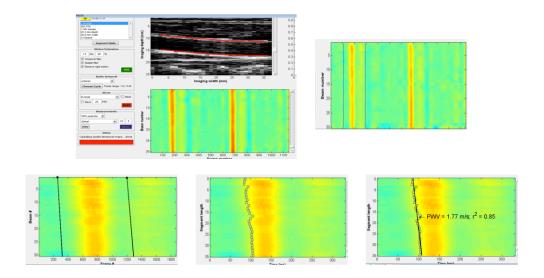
High image quality. The vessel walls are easy to demarcate (ultrasound image) and motion corresponding to two cardiac cycles is obtained. Wave
